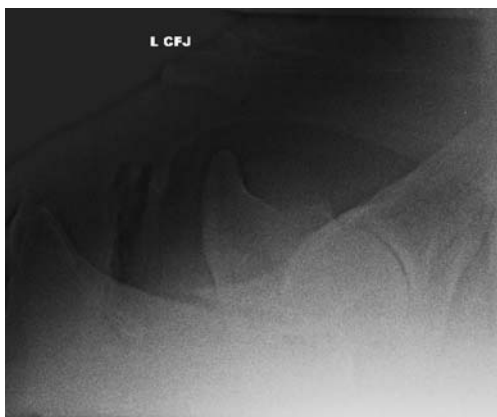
Radiograph of left ischial fracture.
